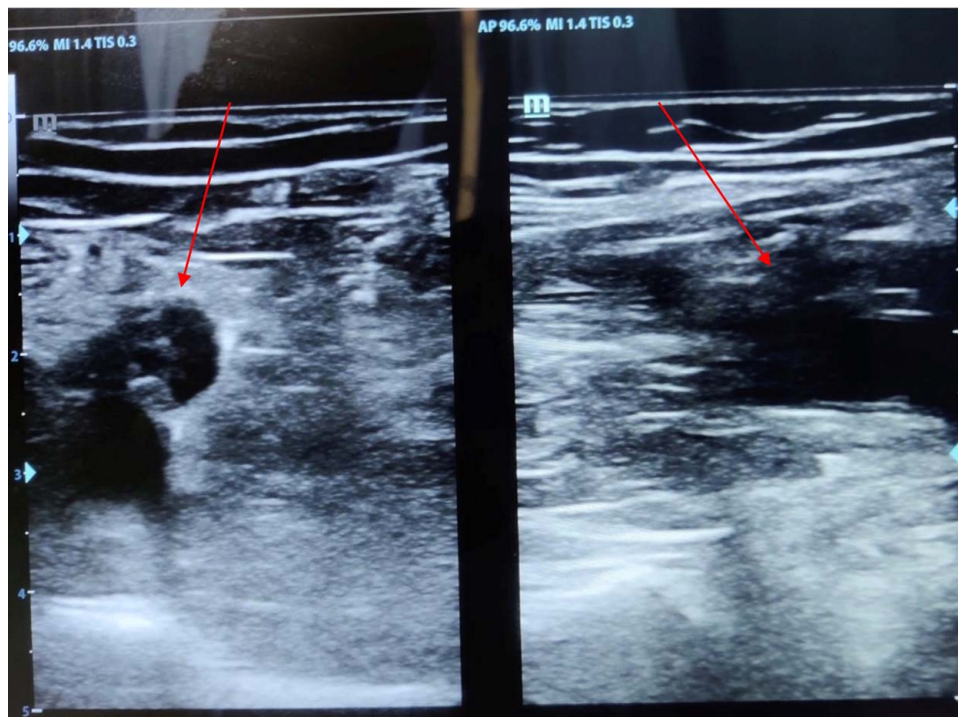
Ultrasonography showing echogenic content within noncompressible popliteal vein. (red arrow).
